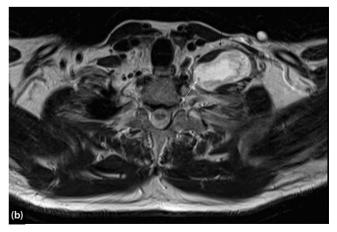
Contrast-enhanced axial CT showing a large lipoma deep to left sternomastoid (white arrow) and compressing the jugular vein. Note the small intramuscular component of the lipoma (black arrow) extending into levator scapulae.
